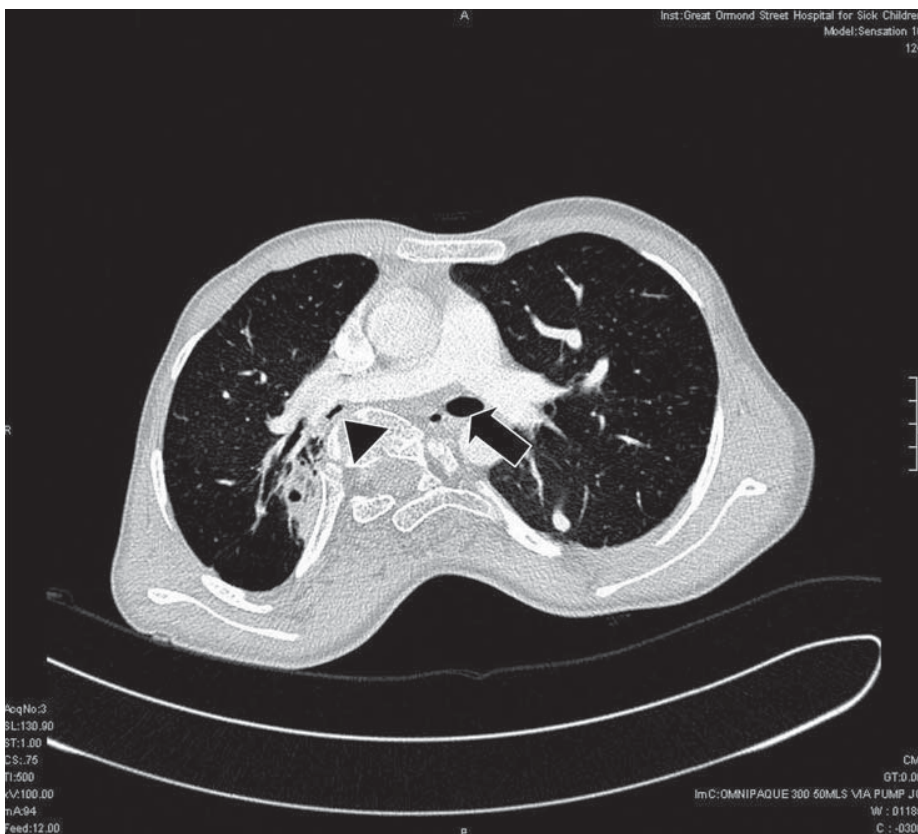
Axial CT of case 2 demonstrating collapse of the right lower lobe bronchus (arrowhead) by compression of the right pulmonary artery and spine. The larger diameter of the unobstructed bronchus to the left lower lobe bronchus is shown as (arrow).
